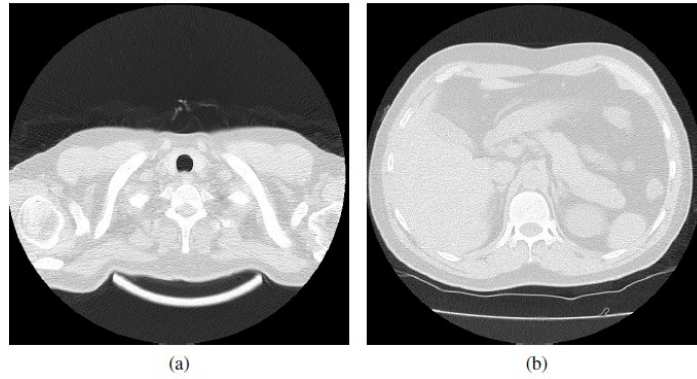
Closed lung at the beginning of CT scan lung sequence (a) and at the end of CT scan lung sequence (b)
